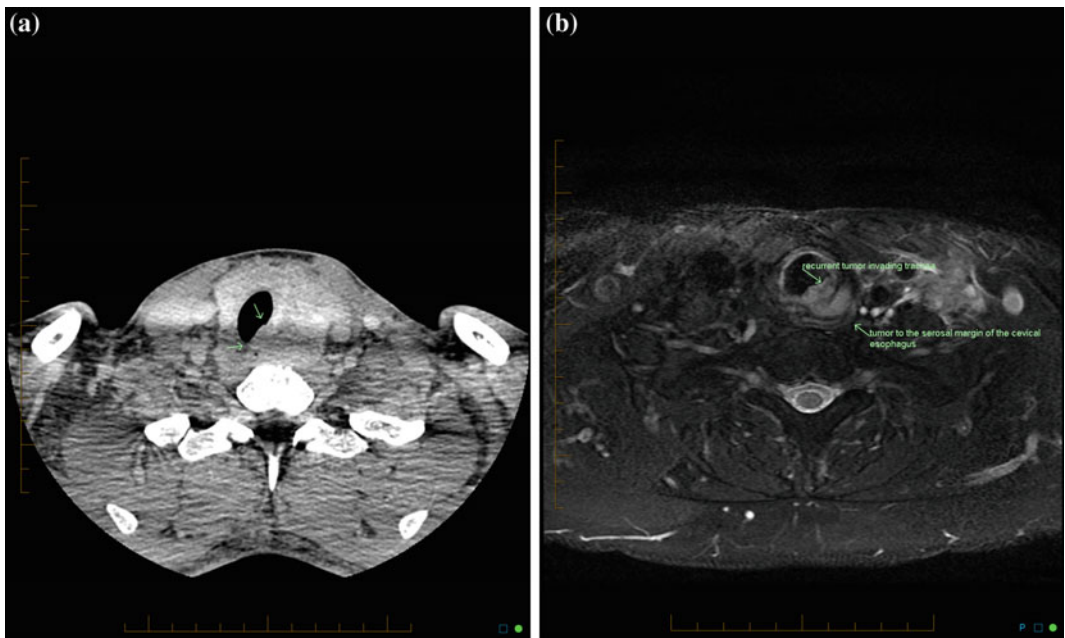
a CT Axial scan demonstrating tracheal and oesophageal invasion with MTC in a patient with MEN2B syndrome. b T2 MRI scan clearly demonstrating the extent of transmural tracheal involvement with tumour. The MRI images complement the CT scan and more precisely elucidate the extent of visceral invasion
